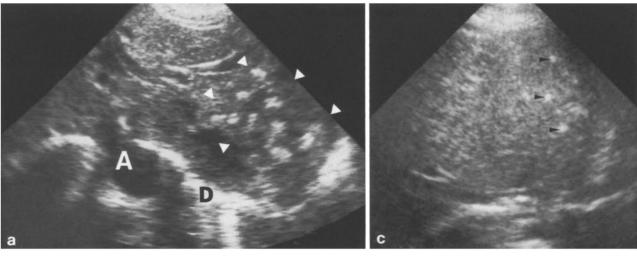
a Transverse sonogram in a 1-day-old boy through the left lobe of the liver shows the diaphragm (D), a dilated aorta (A) and the hemangioendothelioma (arrowheads). b Transverse sonogram at 2 months of age through the left lobe of the liver shows decrease in size of the mass with clusters of calcifications (largest one, arrow). c At 13 months of age a transverse sonogram through the left lobe of the liver shows residual small areas of calcification (arrowheads) with no tumor mass
